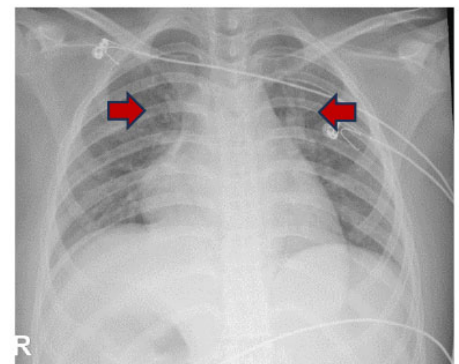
Chest radiograph revealed of pulmonary congestion.
